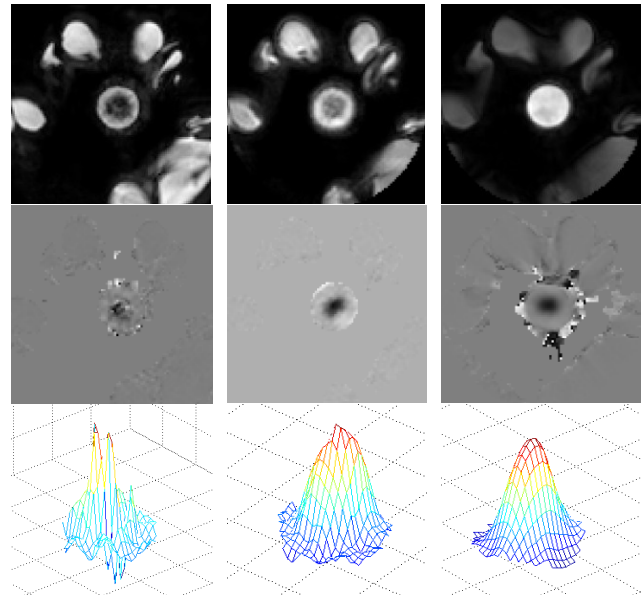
Magnitude image (first row), velocity image (second row), and velocity profile (third row) for high flow rate $Q=300$ mL/s at 33 mm distal to throat of the stenosis for the case of Cartesian (first column), spiral (second column), and 3D UTE (third column) acquisitions. The magnitudes images for Cartesian and spiral sequences show signal loss. The velocity image in the Cartesian acquisition reveals a significant phase error at the center of jet compared to spiral and 3D UTE. There is negligible signal loss and phase error in 3D UTE PC MRI.
